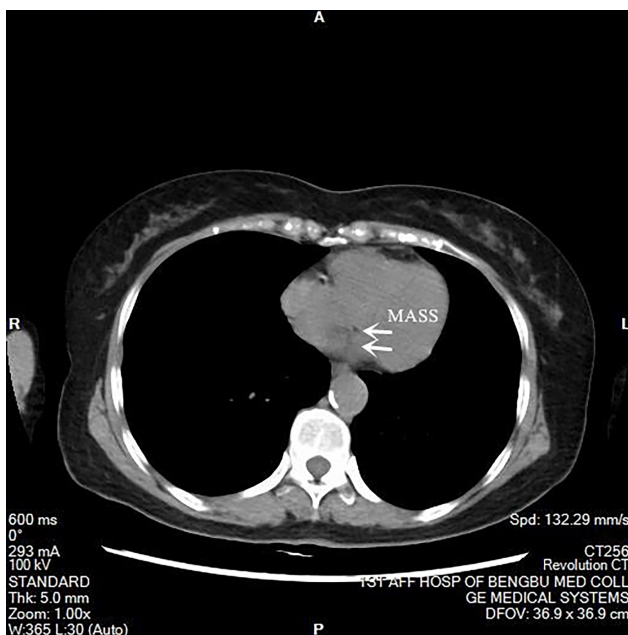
Chest computed tomography shows abnormal nodular hyperdense shadows on the posterior border of the right atrium. The arrow points to MASS, which is the cardiac hemangioma described in this case report.
